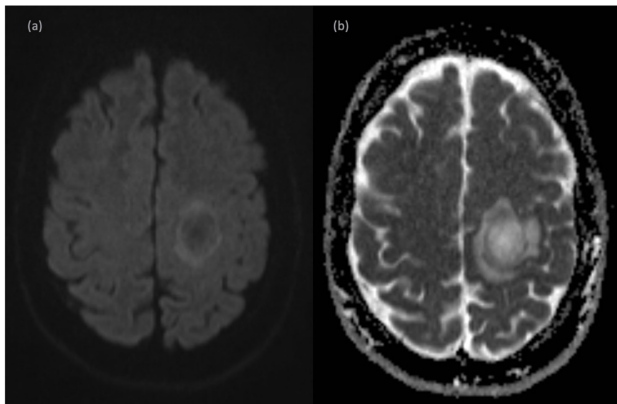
DWI (a) and ADC map (b)
